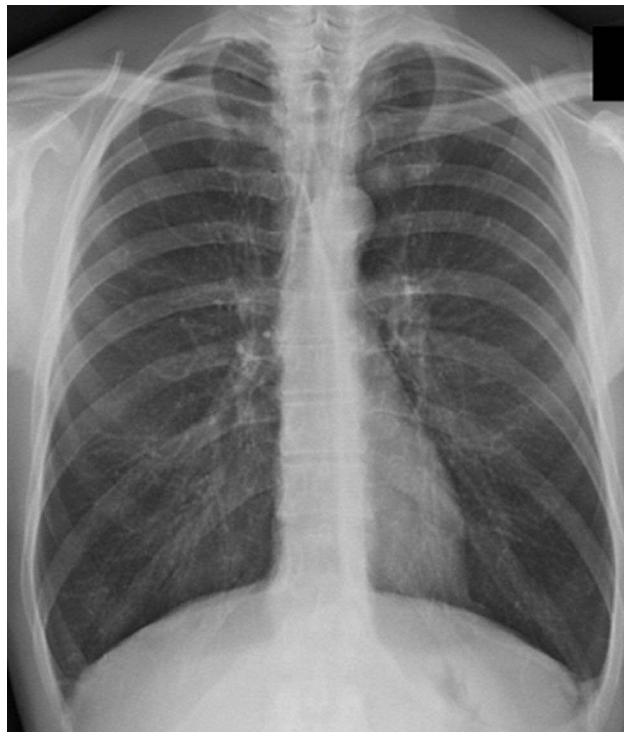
Chest x-ray of a COPD patient showing pulmonary hyperinflation characterized by parenchymal hyperdiaphania and flattening of the diaphragm.
